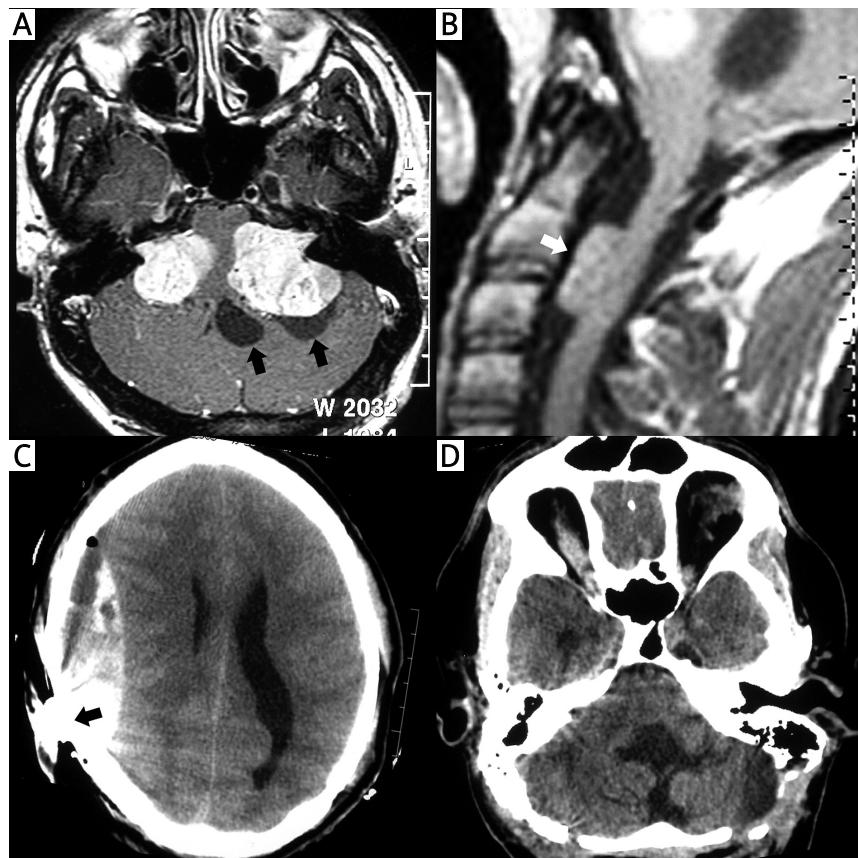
Case 1. Neuroradiological findings. A) T1-weighted MRI image. Bilateral, well-defined CPA tumours with severe brain-stem compression and non-communicating hydrocephalus. The left-sided tumour was accompanied by extratumoral arachnoid cysts (arrows); B) MRI of the spine. Extramedullary meningioma-like mass at the level of C2-C3; C) CT scan revealing an acute supratentorial epidural hematoma on the right side; D) CT scan confirming the complete removal of CPA tumours.
